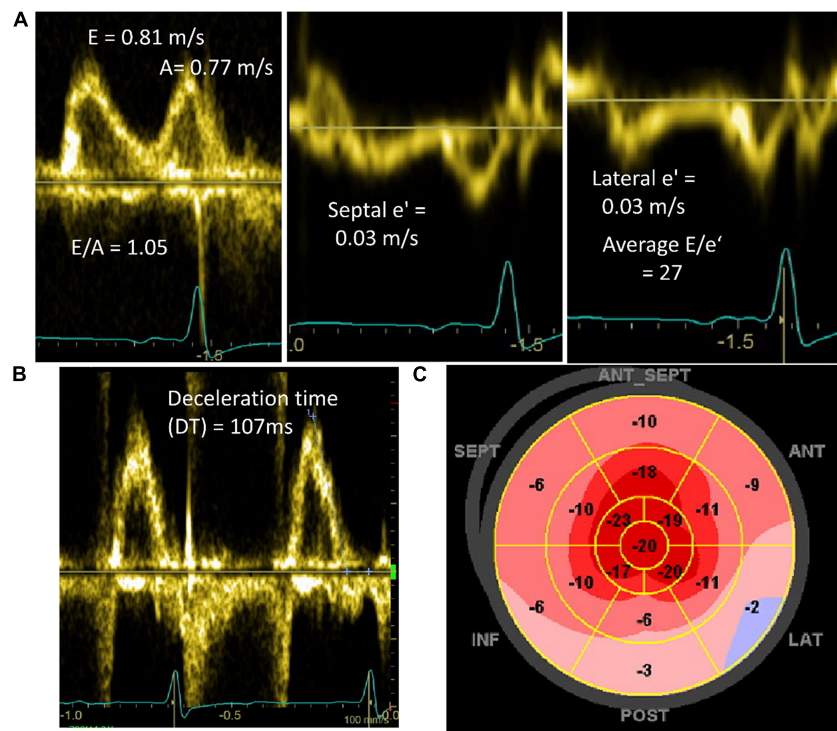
Doppler and longitudinal strain abnormalities in patients diagnosed with cardiac amyloidosis. (A) Mitral inflow and mitral annular tissue Doppler showing pseudonormal diastolic filling (Grade 2) and high E/e' signaling elevated left atrial pressures. (B) Mitral inflow pulse wave Doppler of patient in atrial fibrillation demonstrating short deceleration time (DT) (normal 130–220 ms). (C) Peak systolic longitudinal strain map demonstrating reduced longitudinal strain in basal and mid ventricular segments with relative apical sparing.
